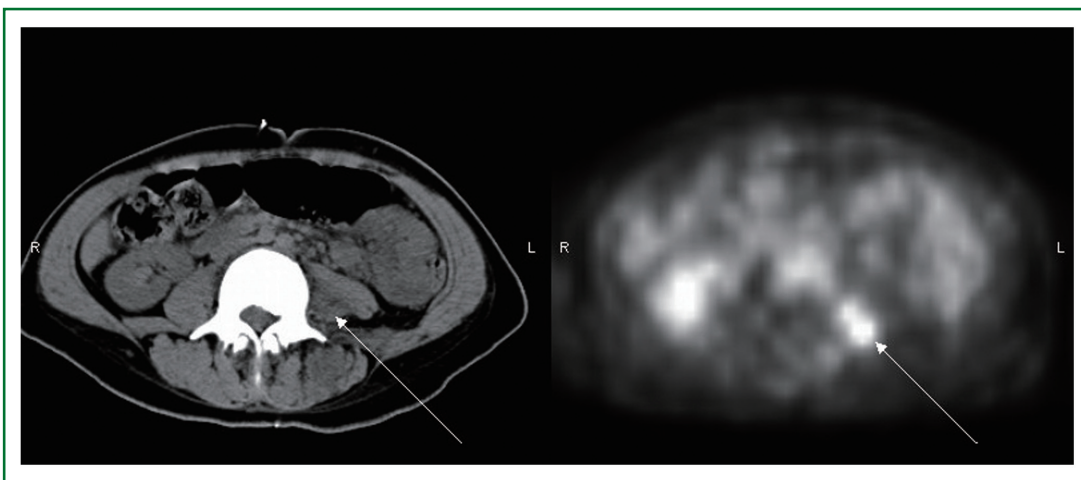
An axial section of a CT scan (left) and a paired axial section of a PET scan (right). The white arrow points to the site of metastatic disease in the left psoas muscle.
